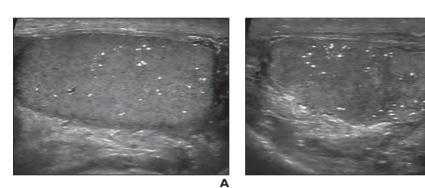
54-year-old man seen in emergency department for testicular pain of 6 months' duration. A and B, Ultrasound images show classic testicular microlithiasis in right (A) and left (B) testicles. More than 5 microliths per image are noted within each testicle. Heterogeneity in upper portion of left testicle (B) was chronic (i.e., stable for decades) and was attributed to sequelae of prior infection or segmental infarct.
